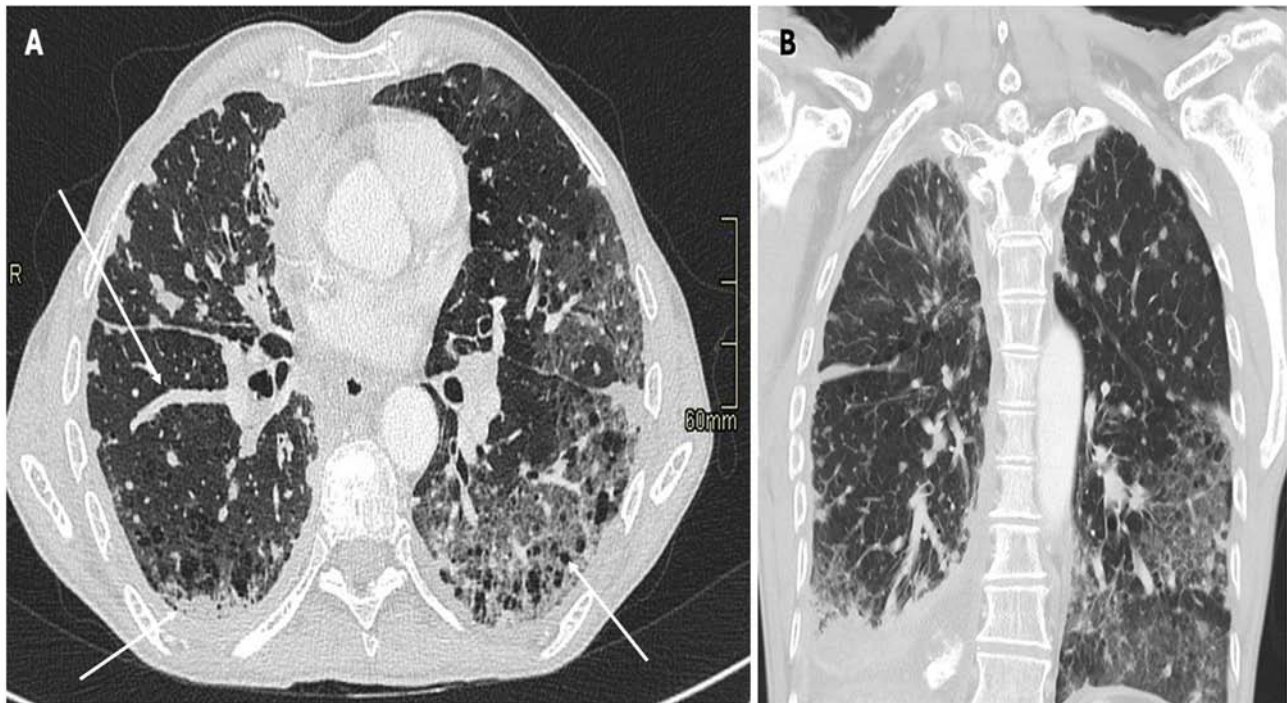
(A) Axial and (B) coronal CT scans with lung parenchyma reconstruction revealed extensive ground-glass opacity predominantly distributed peripherally in the lower lung lobes, accompanied by interstitial septal thickening and more consolidated regions (see arrows). The consolidations are notably pronounced and extensive in the right lower lobe, confirming immunotherapy-induced pneumonia in a 58-year-old patient recently diagnosed with lung adenocarcinoma and undergoing osimertinib therapy.
